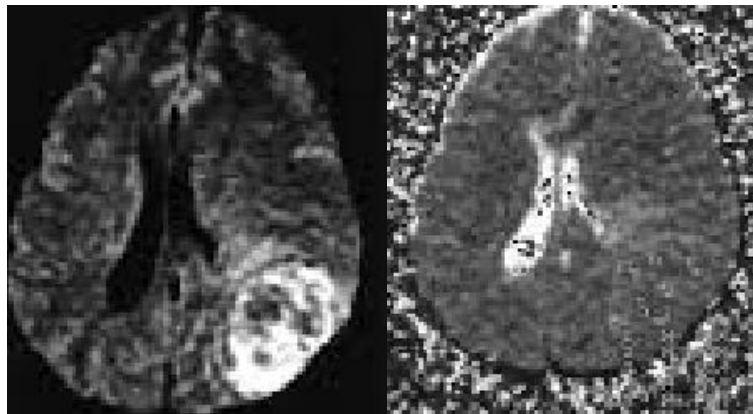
Metastatic tumor from lung cancer in left occipital lobe on DWI shows low signal surrounding by high signal edema
